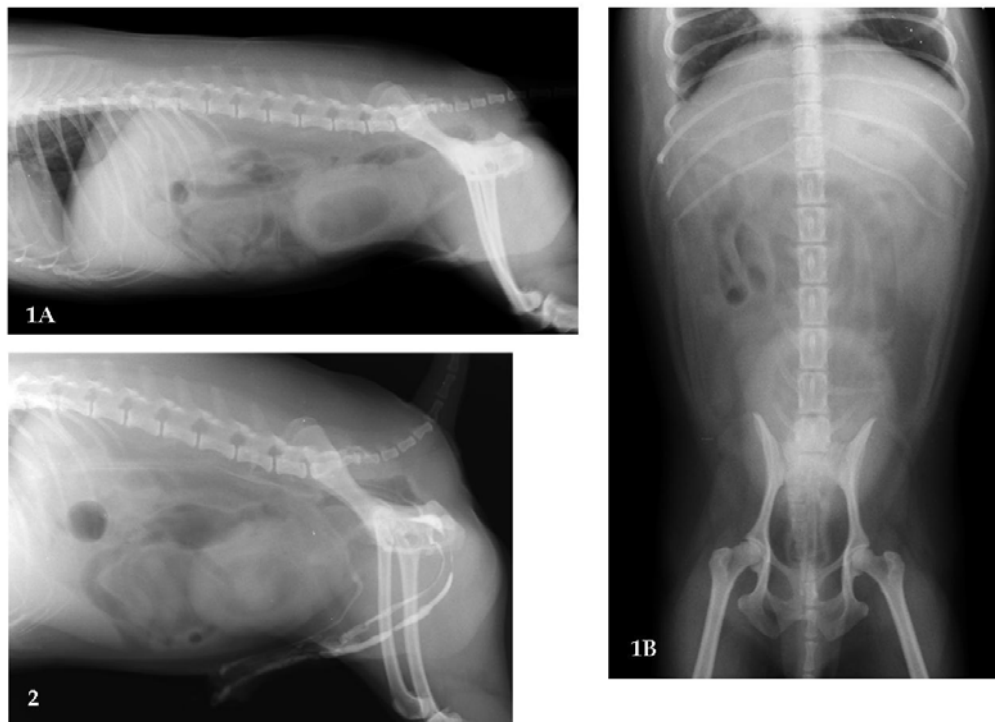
Right lateral and ventrodorsal abdominal radiographs
